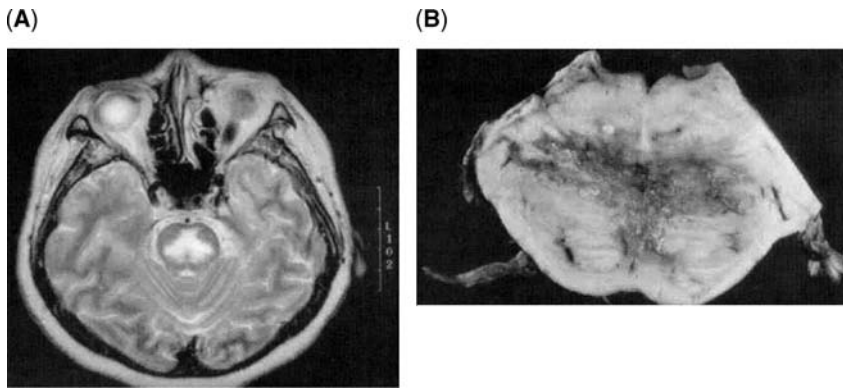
Magnetic resonance imaging and autopsy images of central pontine myelinolysis. (A) T2-weighted magnetic resonance imaging scan showing a symmetrical area of increased signal in the center of the pons, consistent with central pontine myelinolysis. (B) Section of pons with central pontine myelinolysis. *Source:* From Ref. 416.
